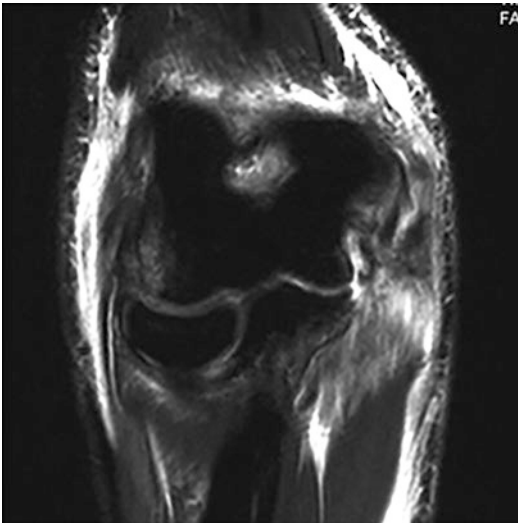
Proton-density sequence MRI of an 18-year-old pitcher with medial elbow pain. Note that the ulnar collateral ligament is completely avulsed from the ulnar attachment (positive “T-sign”)
